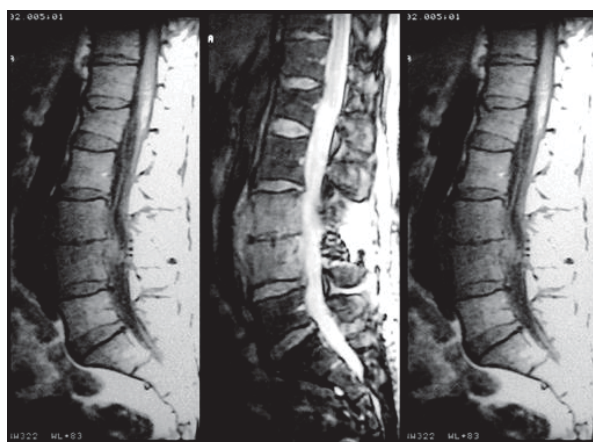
Magnetic resonance imaging of the spine (September 4, 2007) shows spondylodiscitis L3/L4, subdural and prevertebral abscess
